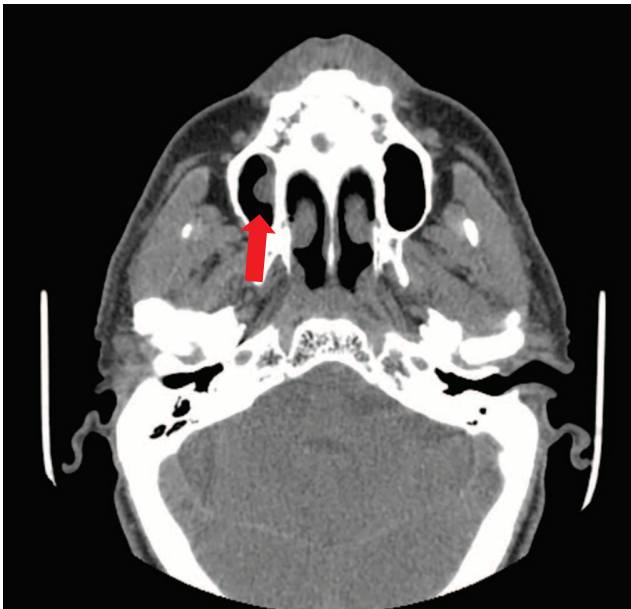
Multislice computed tomography of the paranasal sinuses
